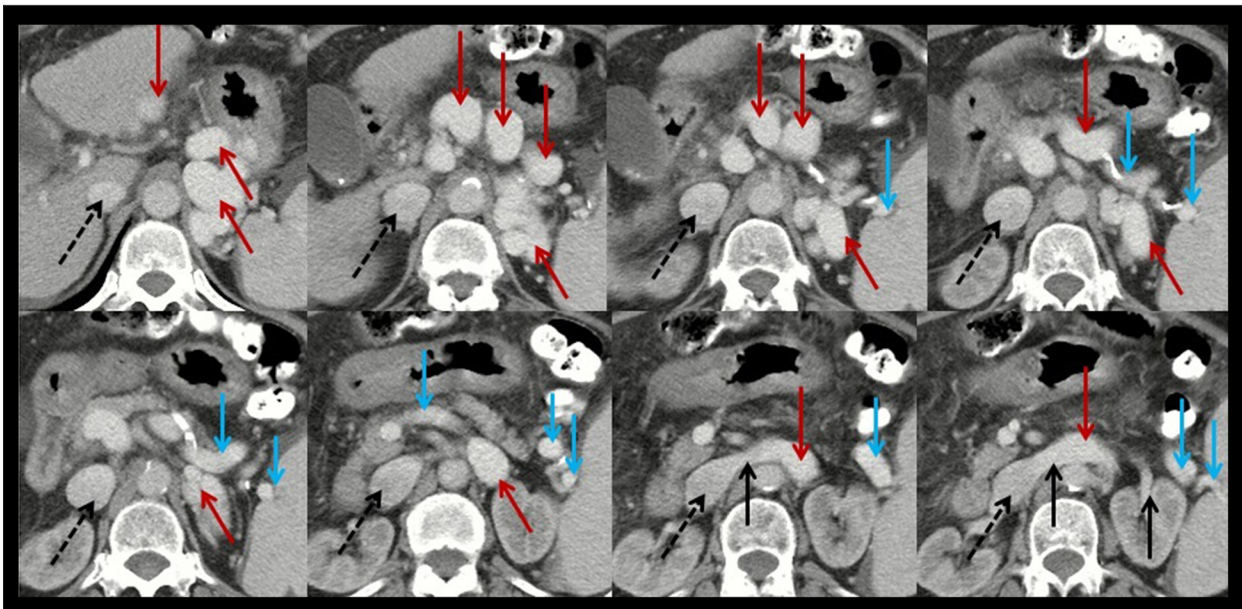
Axial contrast-enhanced computed tomography at the portal vein phase in a 63-year-old female patient with spontaneous splenorenal shunt (HXY). Black dashed arrows represent the inferior vena cava; black solid arrows represent the left renal vein; blue solid arrows represent the splenic vein; red solid arrows represent the communication between splenic vein and left renal vein.
